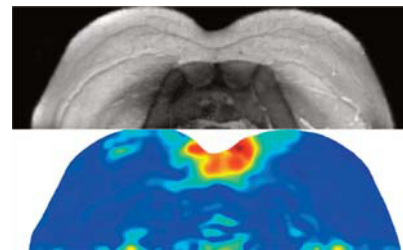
a) Transverse plane MRI, undeformed configuration b) Green-Lagrange shear strain from image registration (on undeformed shape)
